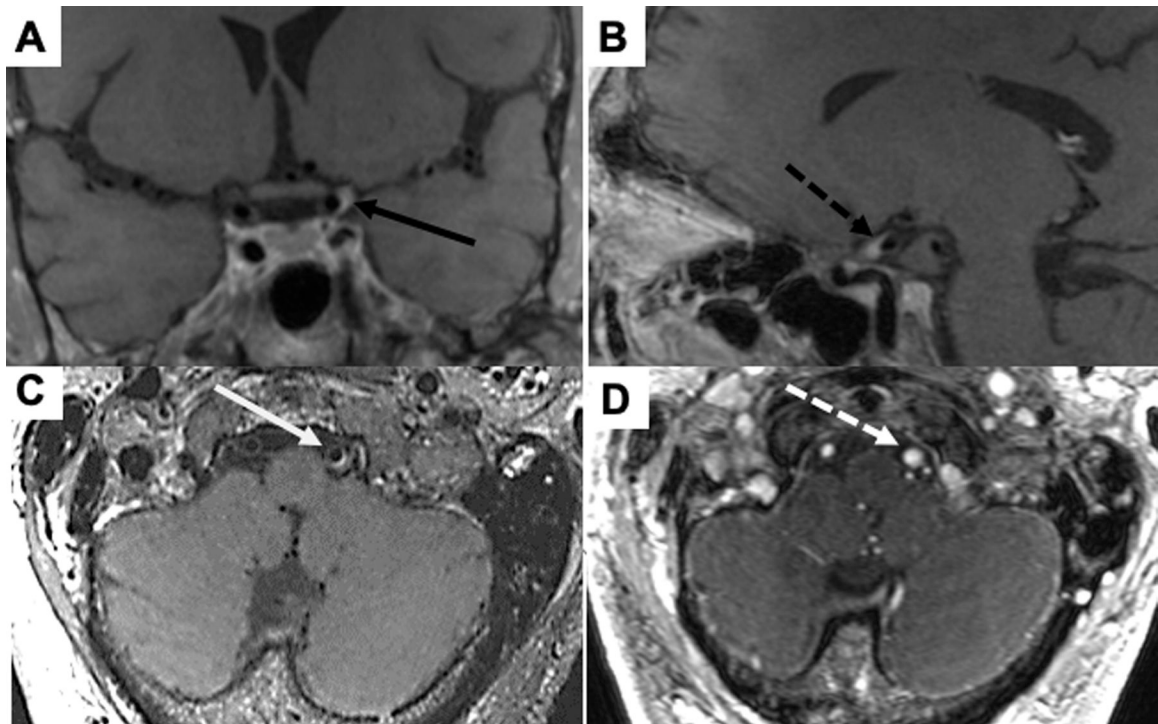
Intracranial arterial wall enhancement on vessel wall MRI (VW-MRI) in participants with HIV infection. (A) Coronal (solid black arrow) and (B) sagittal (dashed black arrow) views of eccentric wall enhancement of the left internal carotid artery of a participant with HIV infection. (C) Eccentric wall enhancement (solid white arrow) of the left vertebral artery with preserved caliber of the vessel on VW-MRI in another participant with HIV. This finding would have gone undetected without VW-MRI, as (D) time-of-flight magnetic resonance angiography showed normal caliber with no luminal narrowing (dashed white arrow).
